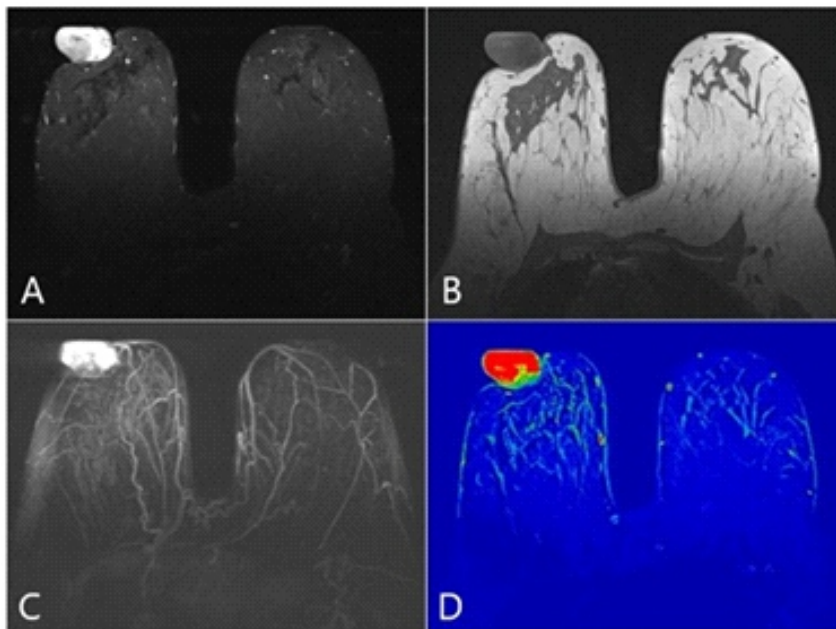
Magnetic resonance imaging of the breast demonstrated an oval mass in the right nipple with a circumscribed margin, with (A) high signal intensity on a STIR sequence; (B) intermediate intensity on a T1 sequence; and (C) intense and heterogeneous enhancement by contrast with no effect on the adjacent breast parenchyma, as demonstrated by maximum intensity projection reconstruction. (D) Colored parametric map showing the increased permeability of the lesion.
